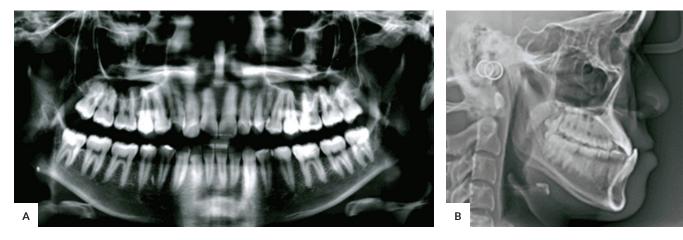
Pretreatment (A) panoramic radiographs and (B) lateral cephalometric.
